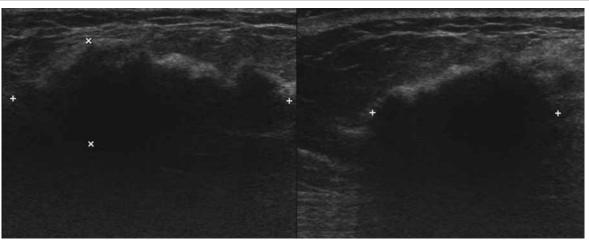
Ultrasonogram of the left breast (transverse and longitudinal images) showing that the palpable lump corresponded to an approximately 4-cm irregular hypoechoic lesion with strong posterior acoustic shadowing at the upper outer quadrant of left breast
